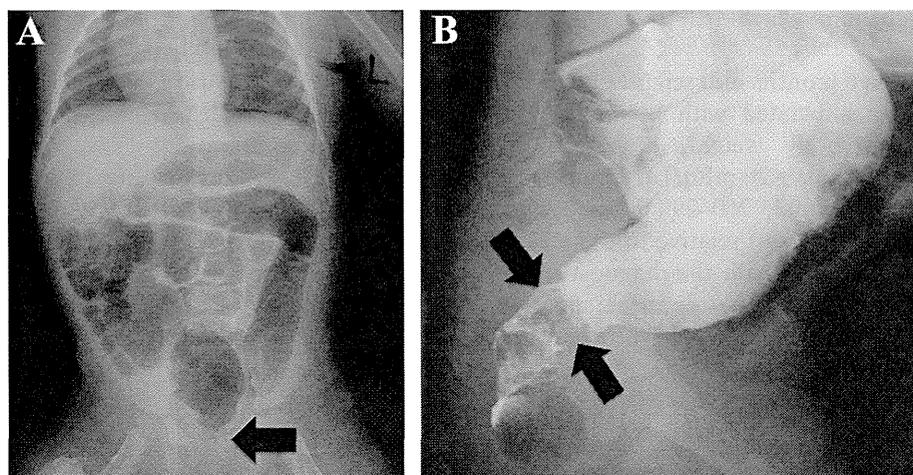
(A) Frontal abdominal radiograph showing marked dilation of the bowel with absence of gas in the rectum (arrow). (B) Lateral view of a barium enema examination at 6 months of age disclosed abnormal narrowing of the rectum (arrow).
